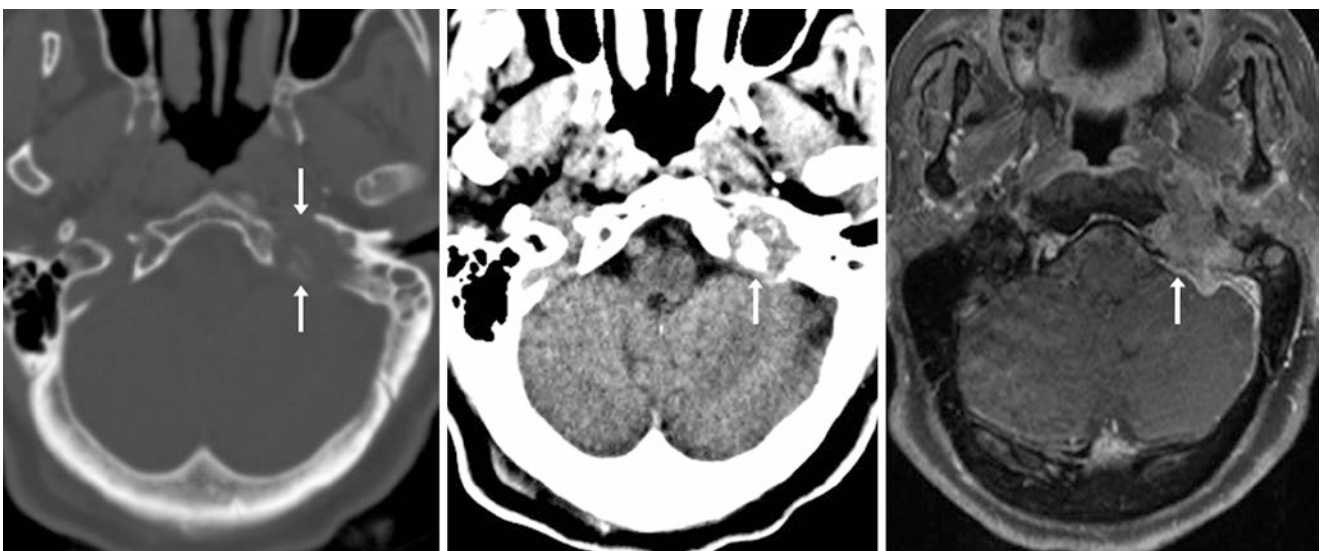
Comparison case of glomus tumor. On NECT bone window (left) and soft tissue window (middle), a glomus tumor enlarges the left jugular foramen, eroding the surrounding temporal and occipital bones. On T1WI MRI (right), it has an irregular border and enhances (arrows)
